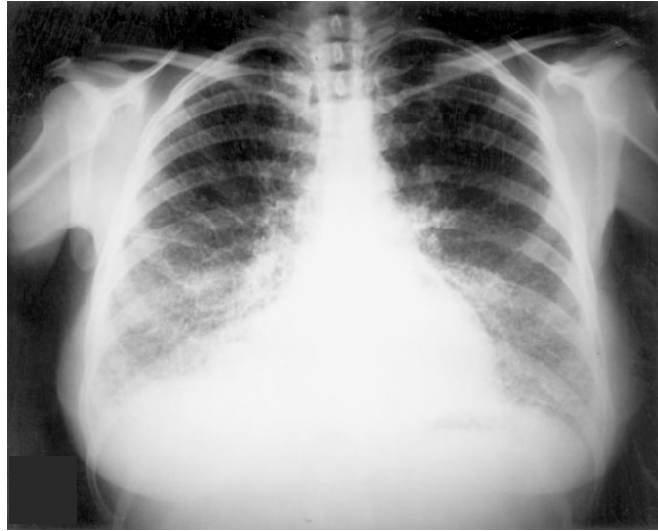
Sandstorm-lung appearance observed in the chest radiograph of a PAM patient. Fine microliths with a diffuse and uniform spreading pattern are observed in the cardiac and diaphragmatic borders (Taken from Castellana et al., 2002).
